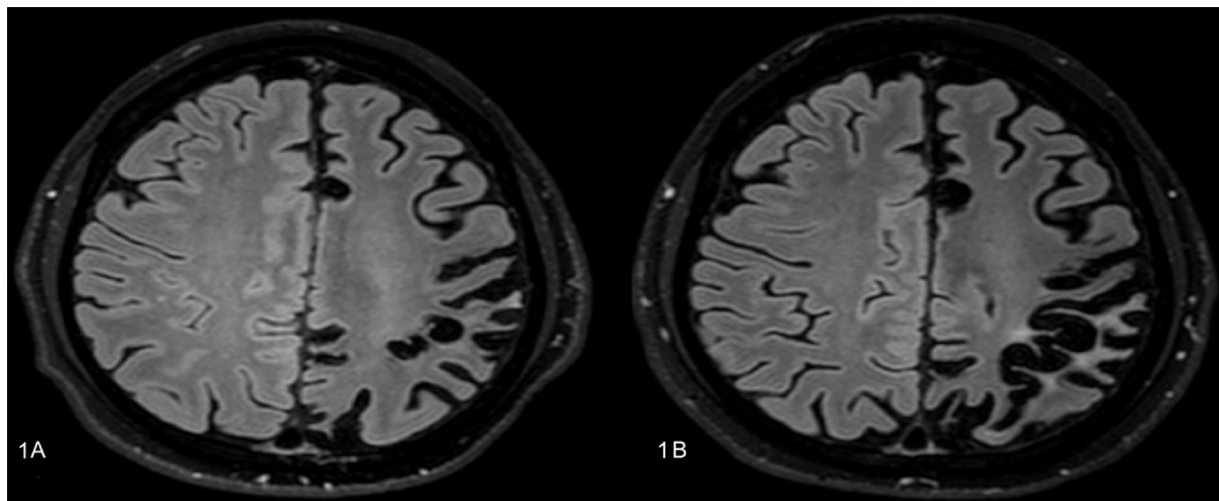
T2/FLAIR MRI brain (axial sections)-Image (A) done at 1.5 years of illness and (B) done six months later revealed progressive left parietal and posterior frontal atrophy.
